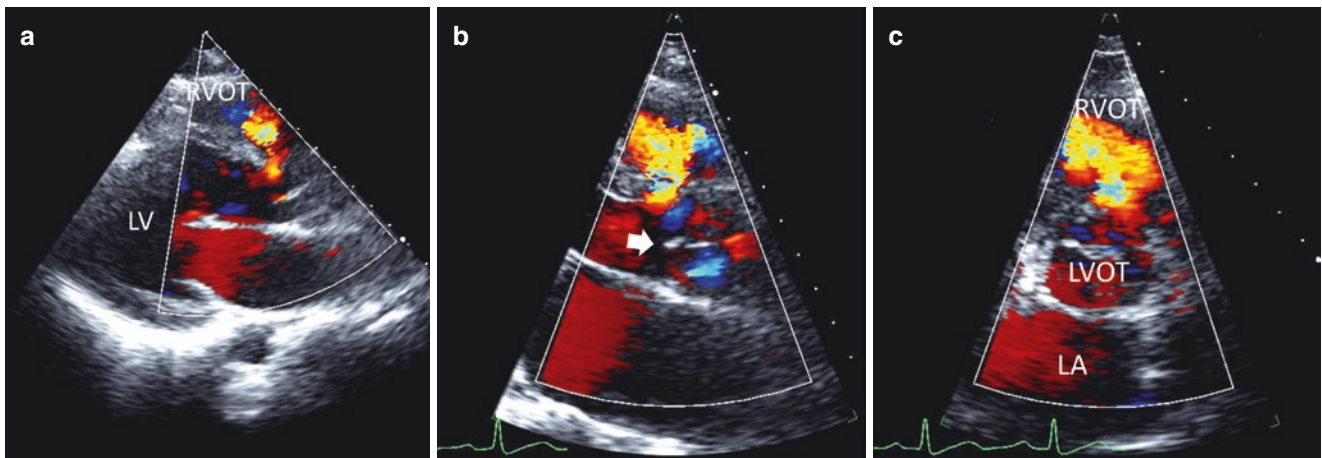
Subarterial ventricular septal defect. (a) Parasternal long-axis view showing left-to-right shunt (red jet) arising immediately below (apical to) the aortic valve. Note left ventricular enlargement, suggesting a significant left-to-right shunt. (b) Parasternal long-axis, zoomed-in view, demonstrating the proximity of the ventricular septal defect to the aortic valve (arrow) and right sinus of Valsalva. (c) Parasternal short-axis view demonstrating the subarterial ventricular
